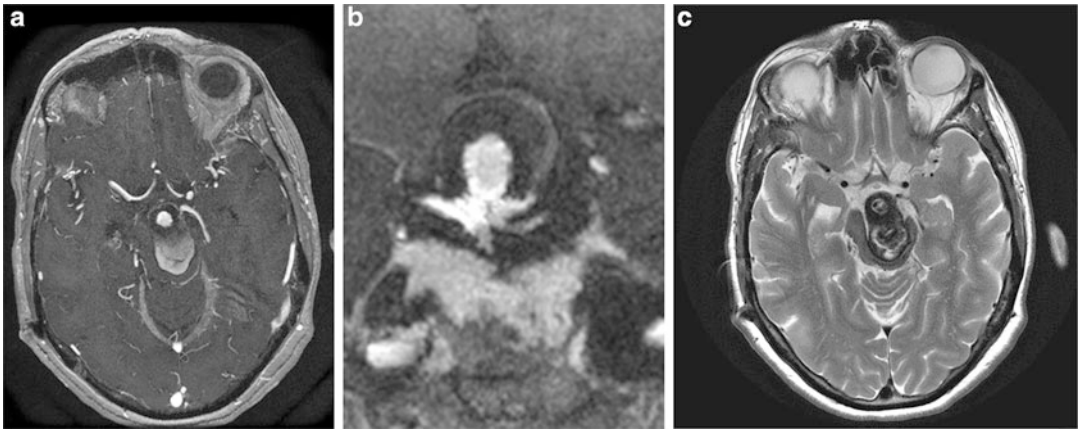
MRI 6 months after the second treatment revealed recanalization of the aneurysm ((a) transverse, (b) coronal
